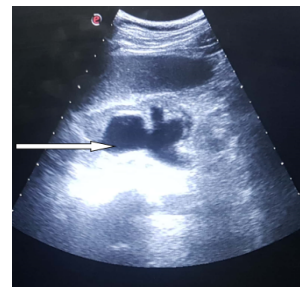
ultrasound image showing the left kidney with the dilated pelvicalyceal system (arrow).
